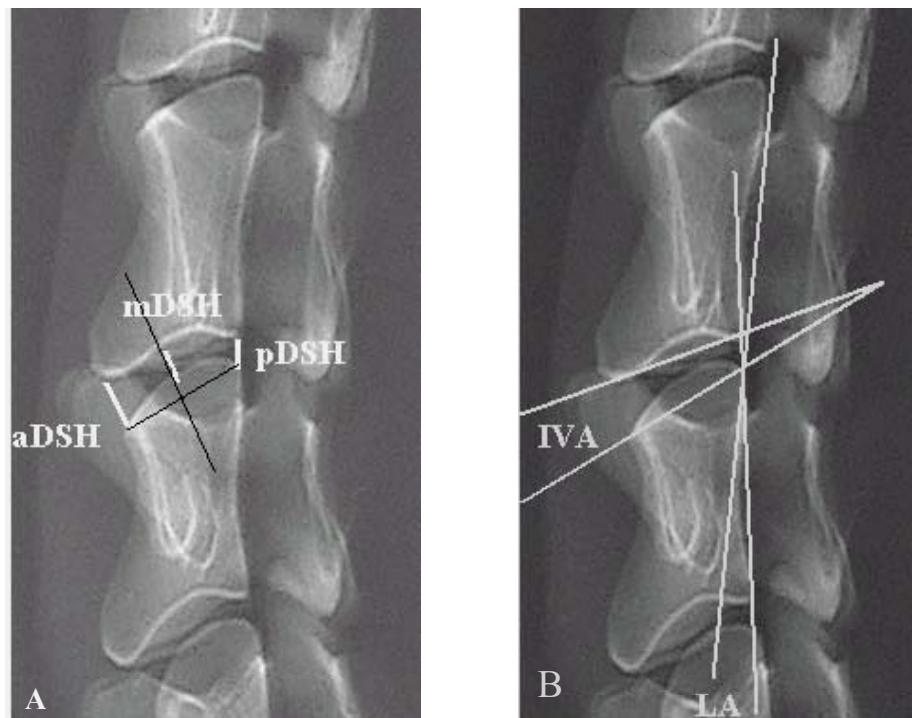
Radiographic measurements of anterior disc space height (aDSH), posterior disc space height (pDSH), middle disc space height (mDSH) (A), intervertebral angle (IVA), and lordosis angle (LA) (B).
